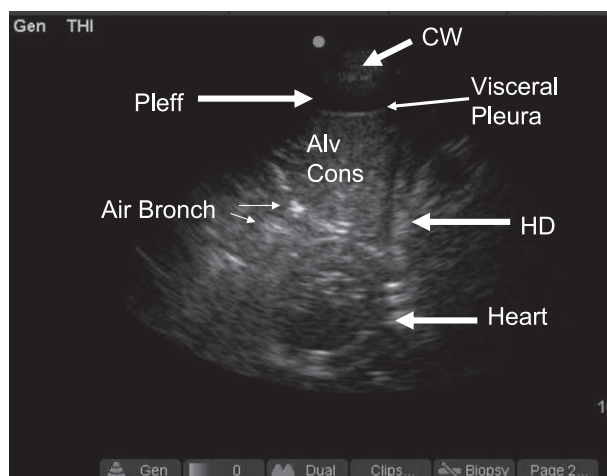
Alveolar consolidation as ultrasound window to mediastinal structures. Longitudinal view midaxillary line on left. Air Bronch = air bronchogram; Alv Cons = alveolar consolidation; CW = chest wall; HD = hemidiaphragm; Pleff = pleural effusion.
